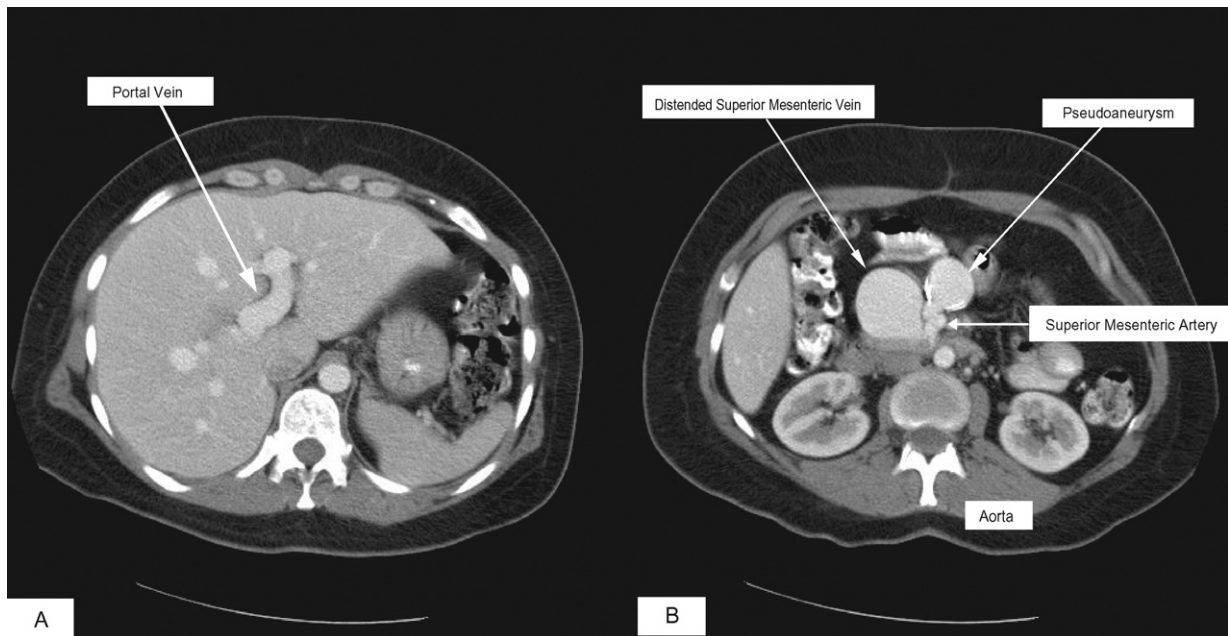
Pretreatment computed tomography scan of abdomen. A, Shows early contrast in a dilated portal venous system (arrow). B, Shows the distended superior mesenteric vein, superior mesenteric artery, and pseudoaneurysm (arrows).
